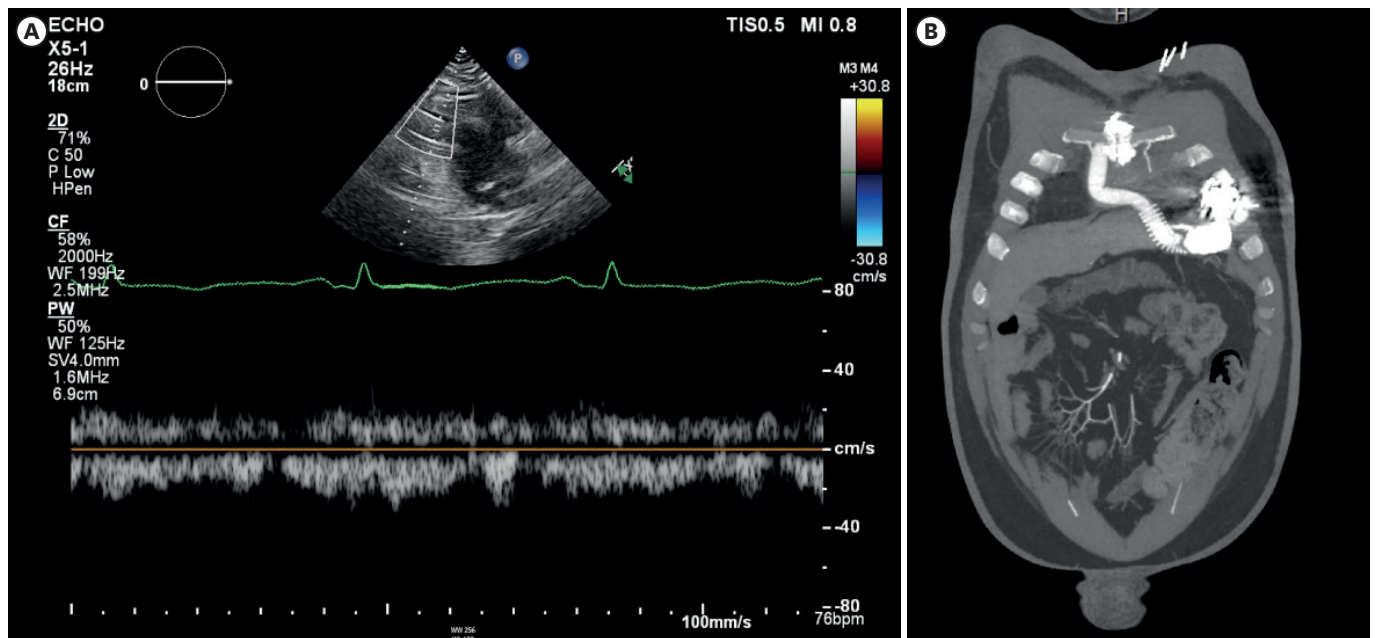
Echocardiographic and CT characterization of pump stop event with no thrombosis. (A) Doppler through outflow graft at pump stop. (B) CT with contrast showing no thrombus at pump stop. CT = computed tomography.
